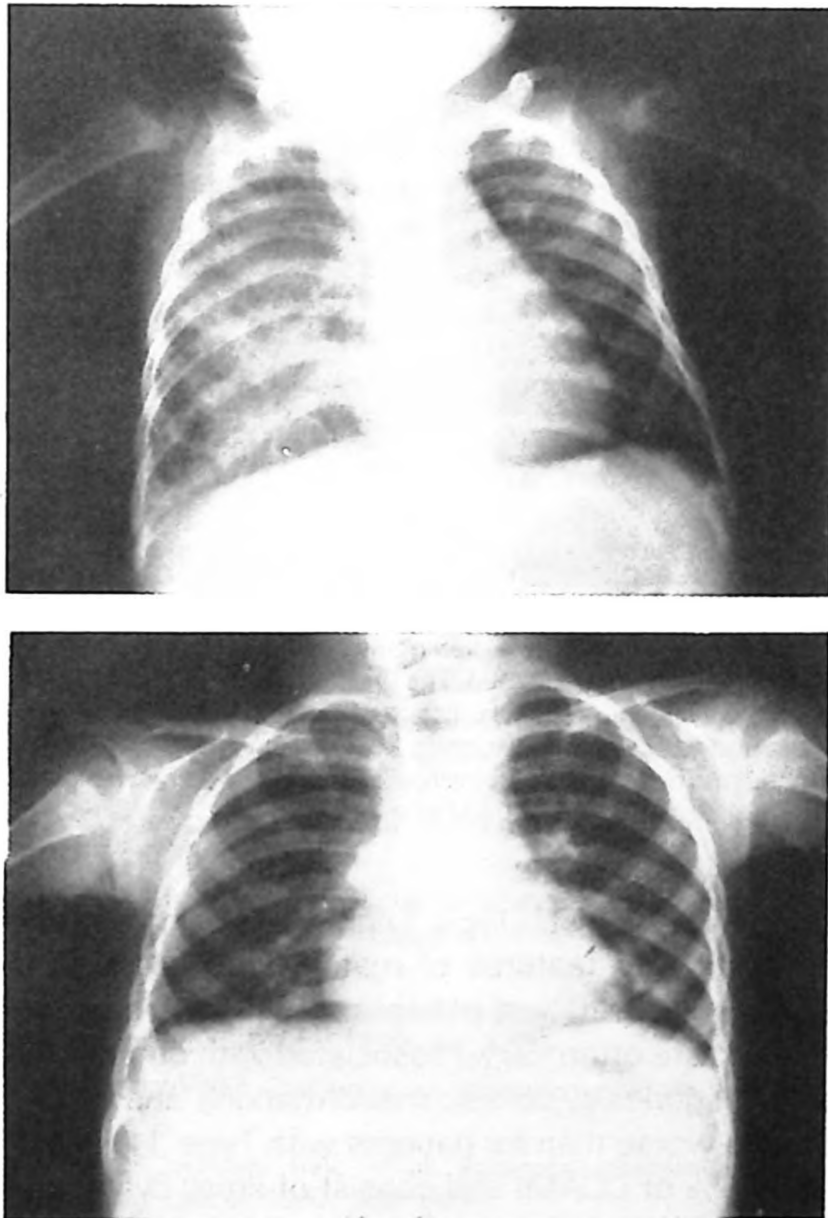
Chest radiography of an infant with CCAM of the right lung, showing multiple cysts of varying sizes and shapes; mediastinum is shifted to the left side. b: Postoperative chest-radiography.
